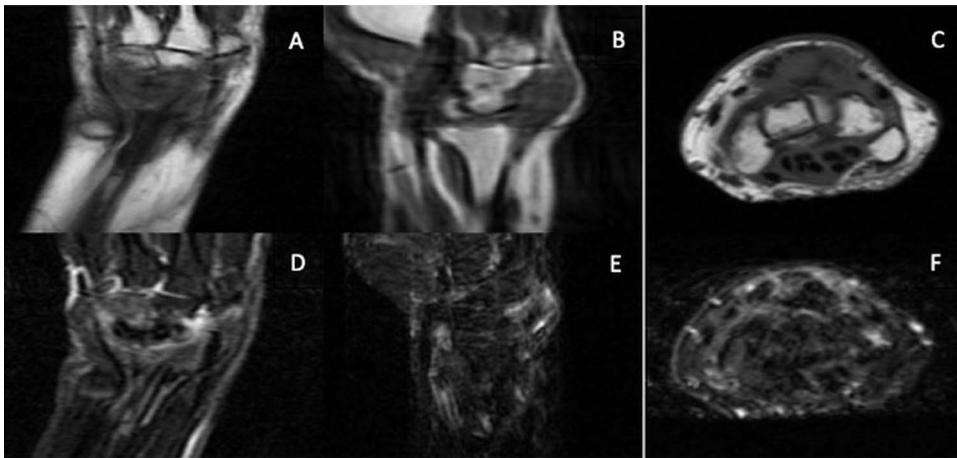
Right magnetic resonance imaging of the right wrist in (A, D) 'coronal,' (B, E) sagittal and (C, F) axial view revealing a dorsal wrist mass.
